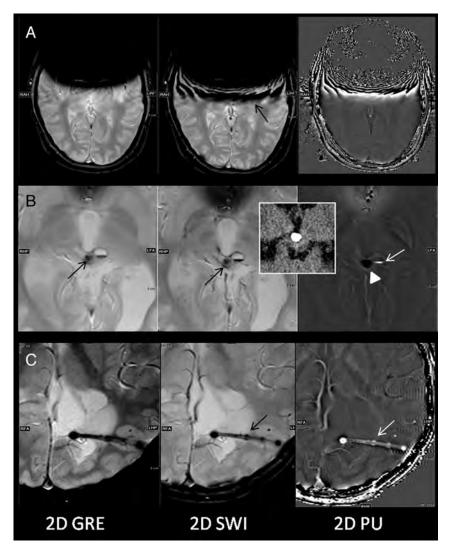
Other comparison features of 2D GRE and 2D SWI/PU. *A*, Dental braces artifacts. Note increased artifacts on 2D SWI (*arrow*) and 2D PU images resulting from dental braces in a 15-year-old boy. *B*, Calcification versus hemorrhage. A T2* lesion (*black arrows*) is detected on both 2D GRE and 2D SWI in a 12-year-old boy previously treated for pineal germinoma. Corresponding 2D PU image shows dark signal (*arrowhead*), opposite of the signal expected for hemorrhage. An adjacent fluid-level lesion demonstrates high intensity typical of hemorrhage (*white arrow*). The presence of calcification is confirmed by prior CT. *C*, Catheter detail. The side holes of the catheter are better delineated on 2D SWI/PU images (*arrows*), particularly on the 2D PU image in an 8-year-old girl with periventricular cyst or encystment. While patency or functionality cannot be assessed by this method, improved catheter detail could be helpful when the position of the side hole relative to the cyst or ventricular system is clinically queried.
